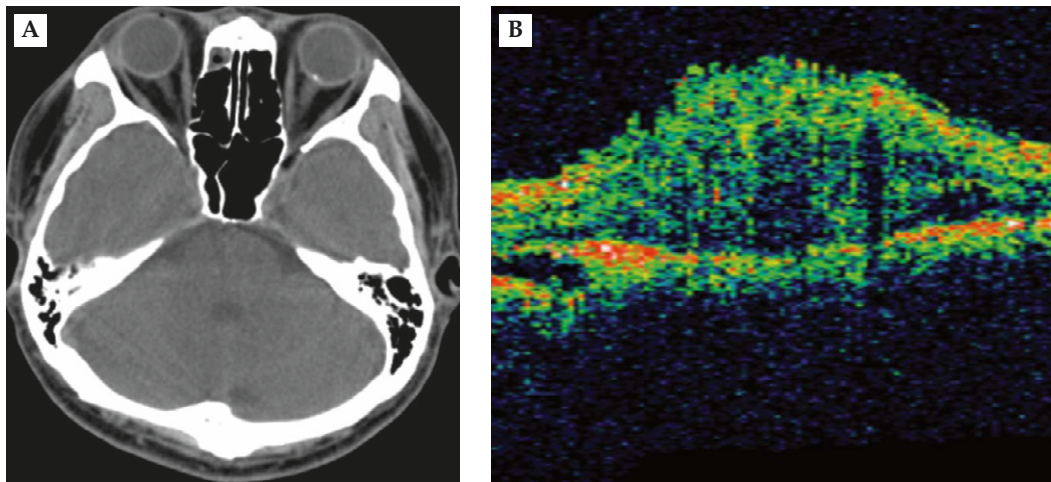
(A) Computed tomography shows a calcifying mass in the left optic disc. (B) Vertical optical coherence tomography scan reveals elevated, hyperreflective lesion with underlying hyporeflective shadowing. The retinal thickness is 300 μm .
